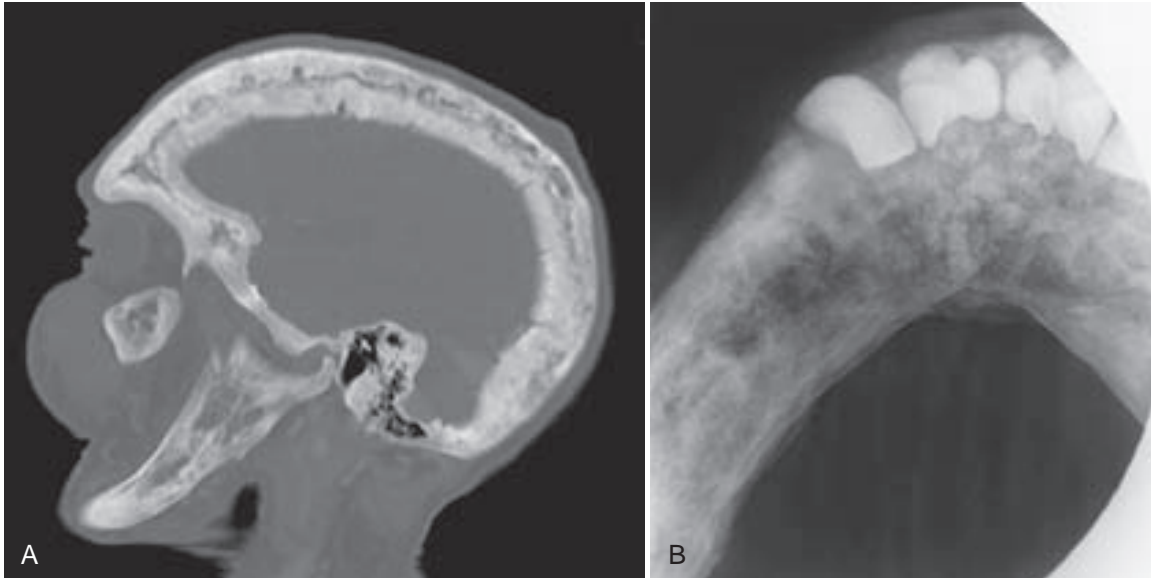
Paget disease of bone (osteitis deformans). A, Sagittal CT shows thickened cranial bones, maxilla and mandible, and an increase in bone density. B, Occlusal radiograph shows mottled radiolucency/opacity of the mandible. (From White SC, Pharoah MJ: Oral Radiology: Principles and Interpretation. 6th ed. St. Louis, Mosby, 2009.)
